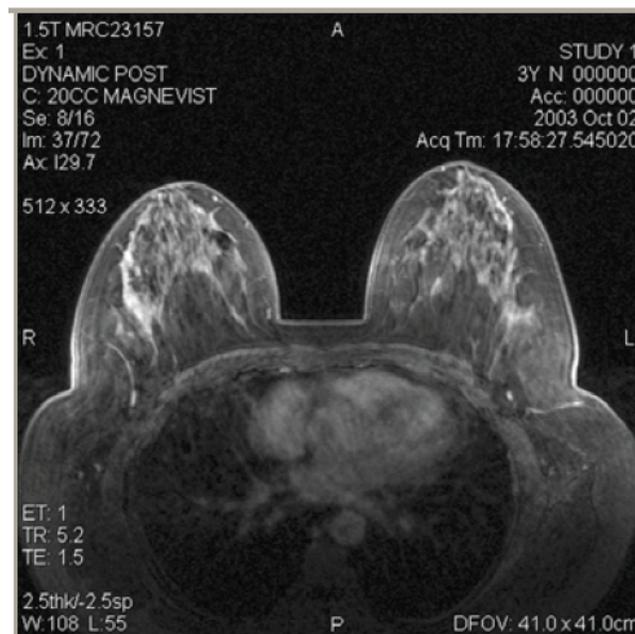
Bilateral MRI of the breast, imaged at 1.5T (Courtesy of Insight Neuroimaging Systems, LLC.).
